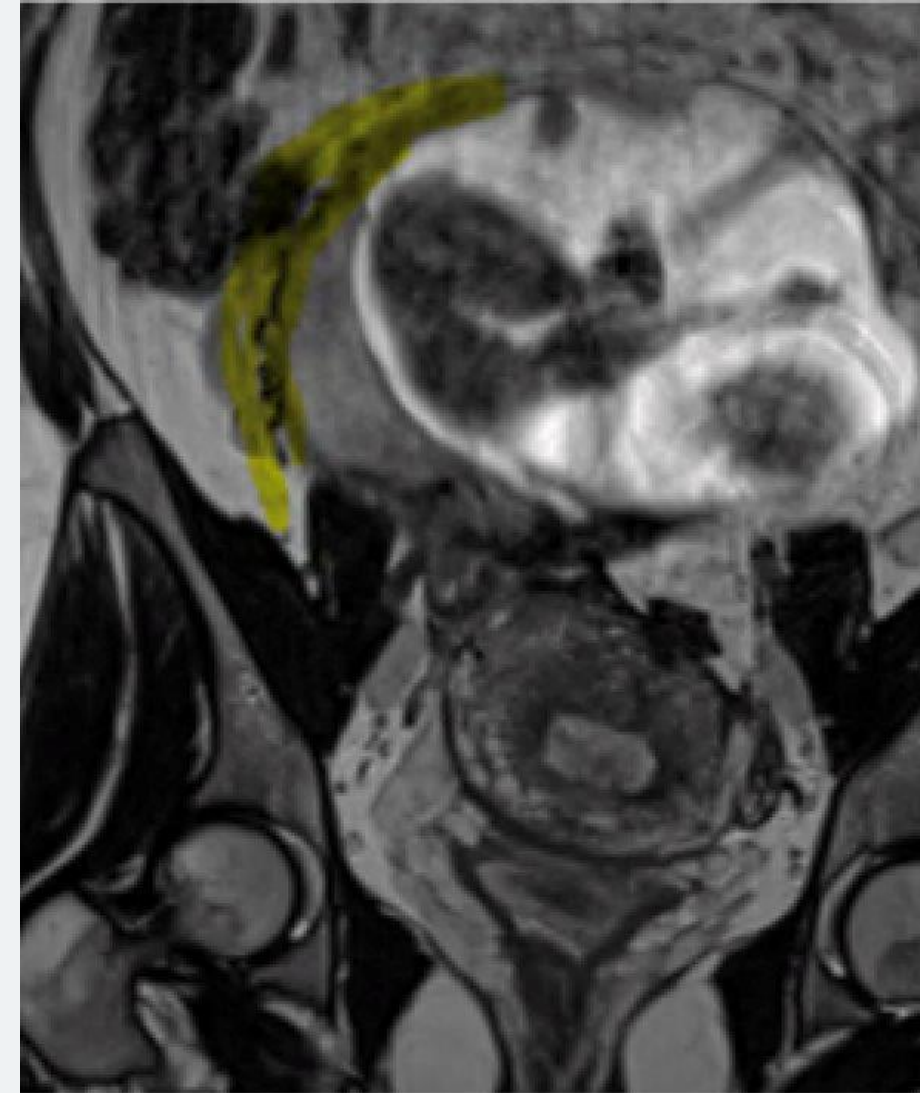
MRI Abdomen/Pelvis showing advanced ectopic pregnancy within the central abdomen, adherent to the anterior and lower segment of the uterine wall of the retroverted uterus.
